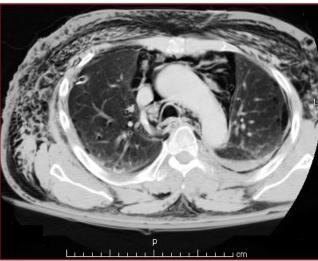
Representative CT of pneumomediastinum and subcutaneous air 17
